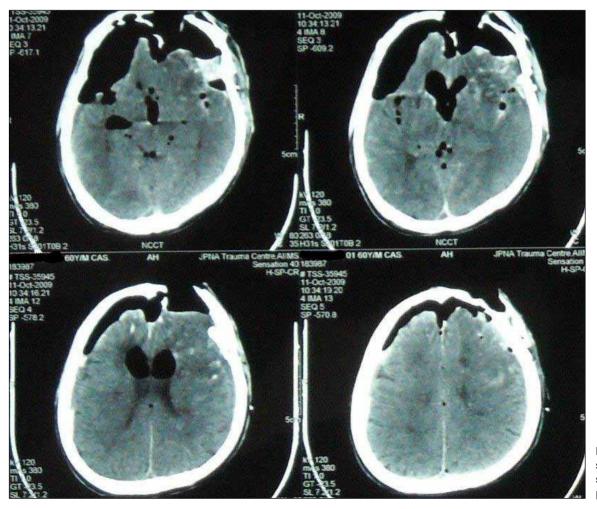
CT scan of Case 4 shows tension pneumocephalus.
